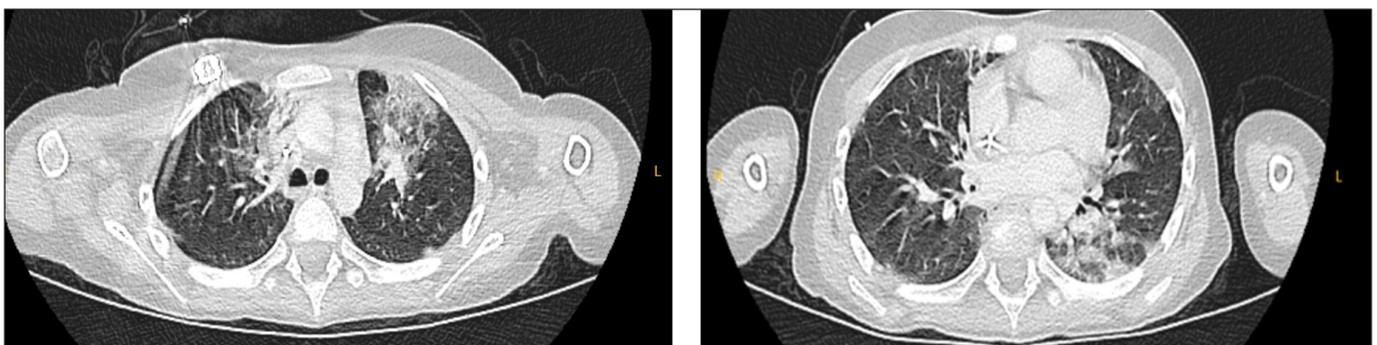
A computed tomographic scan of the chest showing bilateral air bronchograms and patchy consolidation
